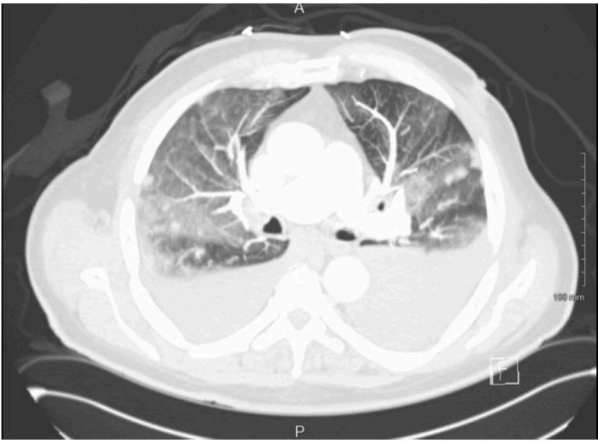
CT Angiogram of the Thorax shows bilateral airspace disease probably represents alveolar edema with large bilateral pleural effusions.
